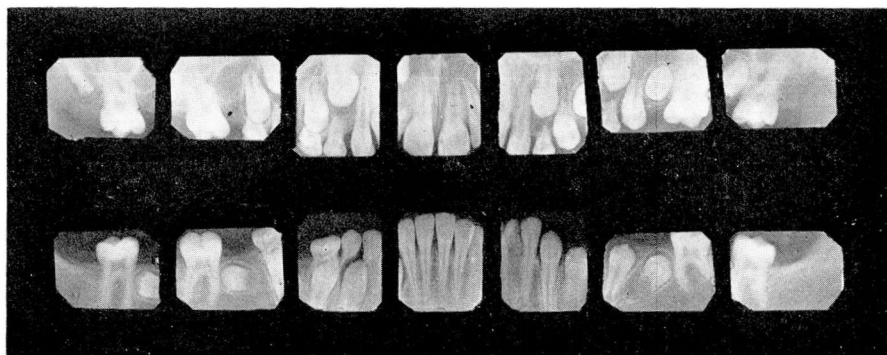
Roentgenograms of teeth of child aged 10.
